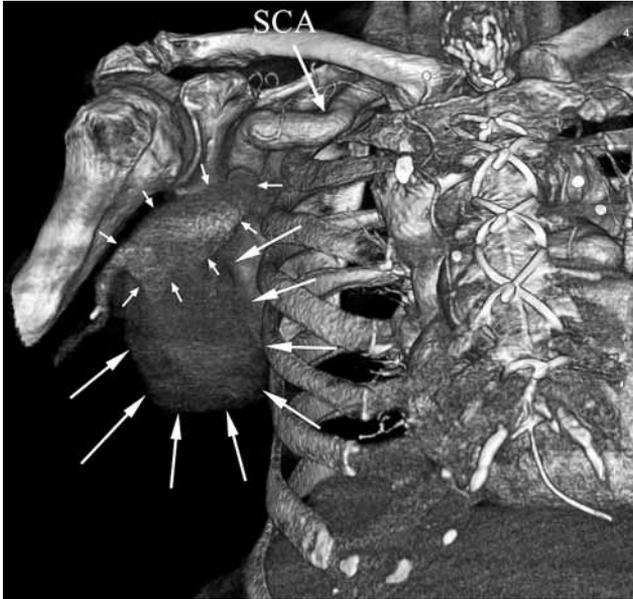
Computed tomography angiography shows the saccular axillary artery aneurysm. The small arrows indicate the border of the axillary artery aneurysm, and the large arrows show the border of the hematoma. SCA: Subclavian artery.
